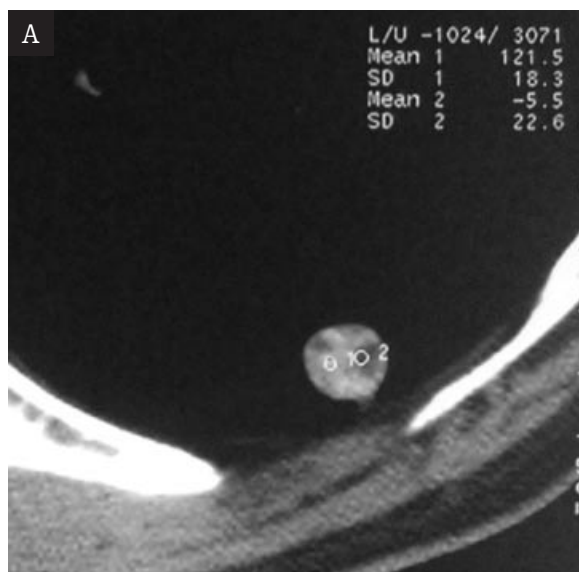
Different morphology of hamartoma (adipose tissue, calcifications) visible in CT examination.
